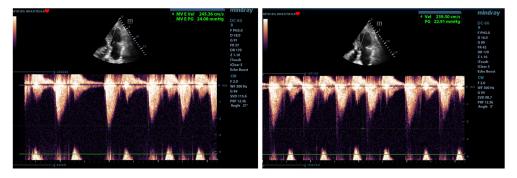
b.8. Evaluation of maximum gradient at transaortic valve level 24 mmHg (left) and at LVOT level 22 mmHg (right) (CW Doppler, apical 5-chambers view)
